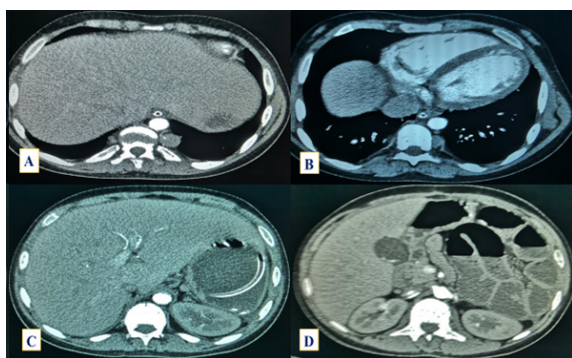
A) Axial CT abdomen shows huge hepatomegaly, left lobe focal low attenuation left paraspinous soft tissue masses. B) Axial contrast-enhanced lower chest mediastinal CT scan, arterial phase, nasogastric tube noted. No pericardial and pleural effusions; left paraspinous lobulated masses. C) Abdomen CT: hepatomegaly, dilated stomach, and nasogastric tube. Normal enhanced left kidney and PV. D) Axial contrast-enhanced CT scan, venous phase. Dilated bowel, pseudo-obstruction, GB stones, and nasogastric tube tip.
